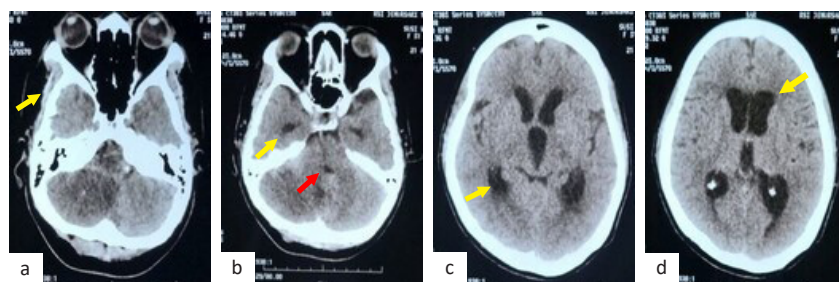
The unenhanced computed tomography (CT) scan. (a) Nonspecific hypoattenuating mass of the right cerebellar hemisphere extending to the vermis (yellow arrow); (b) mass pushed fourth ventricle to the left side (red arrow), temporal horns are dilated (yellow arrow); (c) dilatation of posterior horn of lateral ventricle (yellow arrow) confirming obstructive hydrocephalus; (d) periventricular edema also present (yellow arrow)
